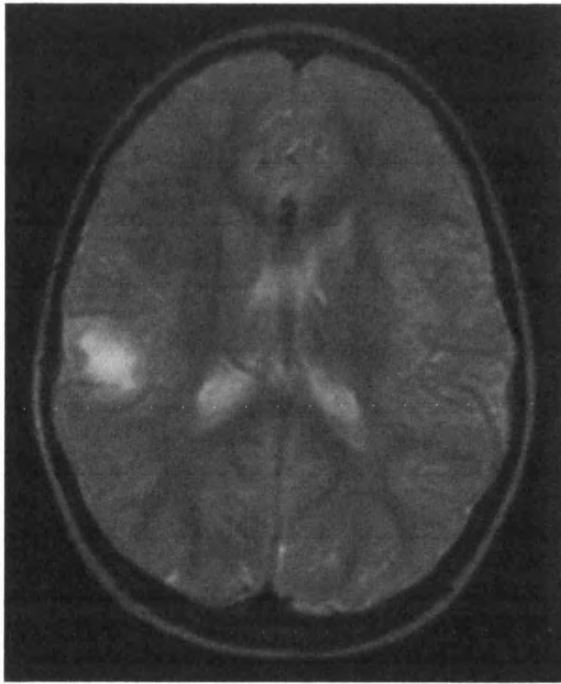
Figure eight – Cortical tuber (MRI FLAIR)
